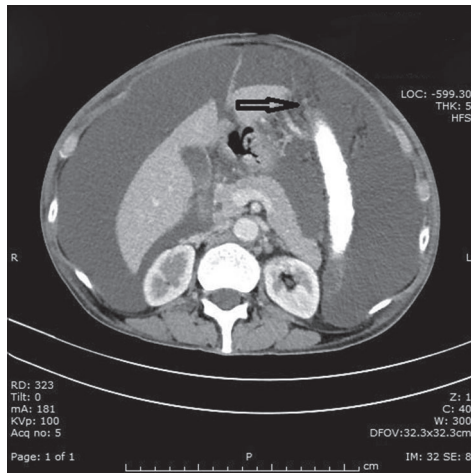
The computed tomography (CT) scan. The CT data show diffuse nodular thickening (black arrow) of the omentum and ascites
